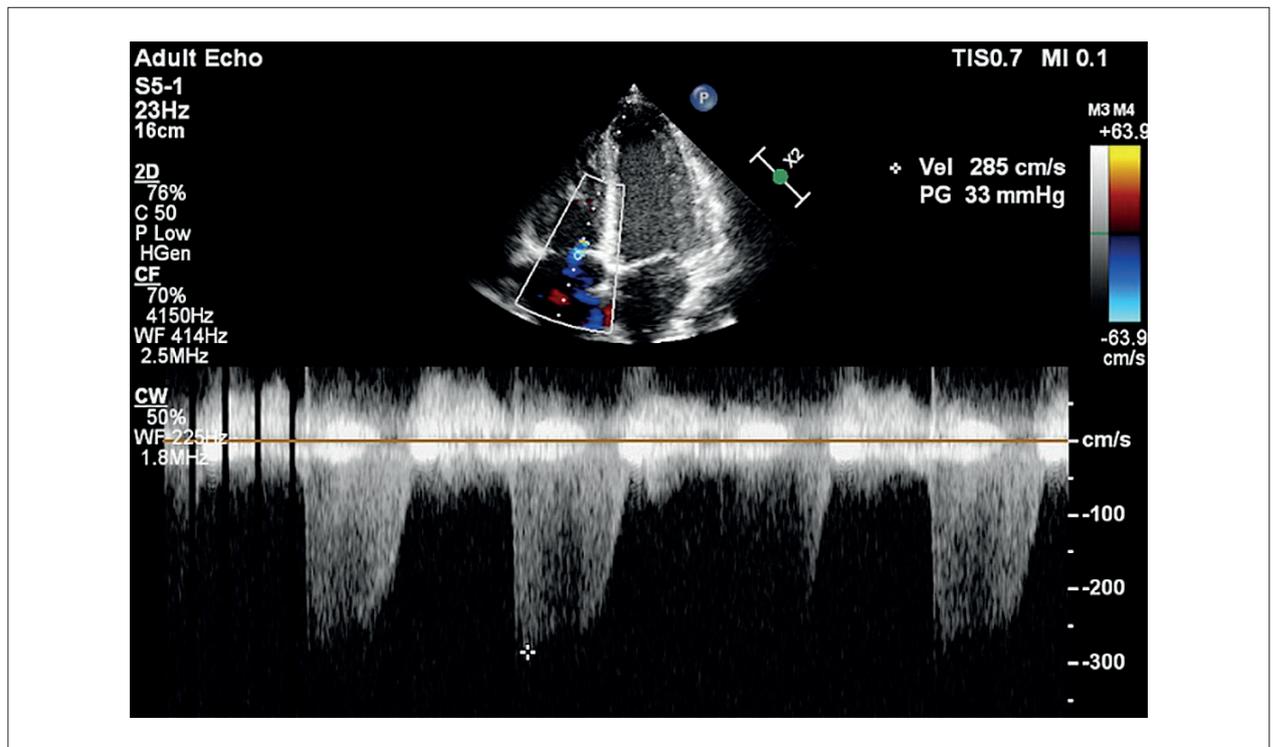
Apical 4-chamber view for the analysis of tricuspid regurgitation using continuous Doppler in a patient with SCD. PG: Pressure Gradient; CW: Continuous Wave Doppler; WF: Waveform; CF: Color Flow Doppler
